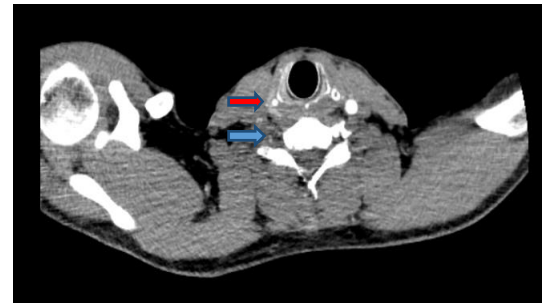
The axial slice of CT angiography at the level of the sixth vertebral body, related to common carotid artery, shows a complete filling defect in right common carotid artery (red arrow) and right vertebral artery (blue arrow).
